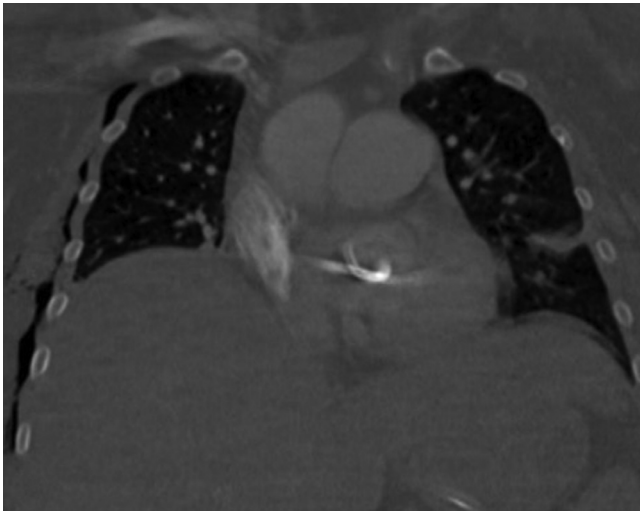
Chest CT coronal image demonstrates chest tube within the heart.
